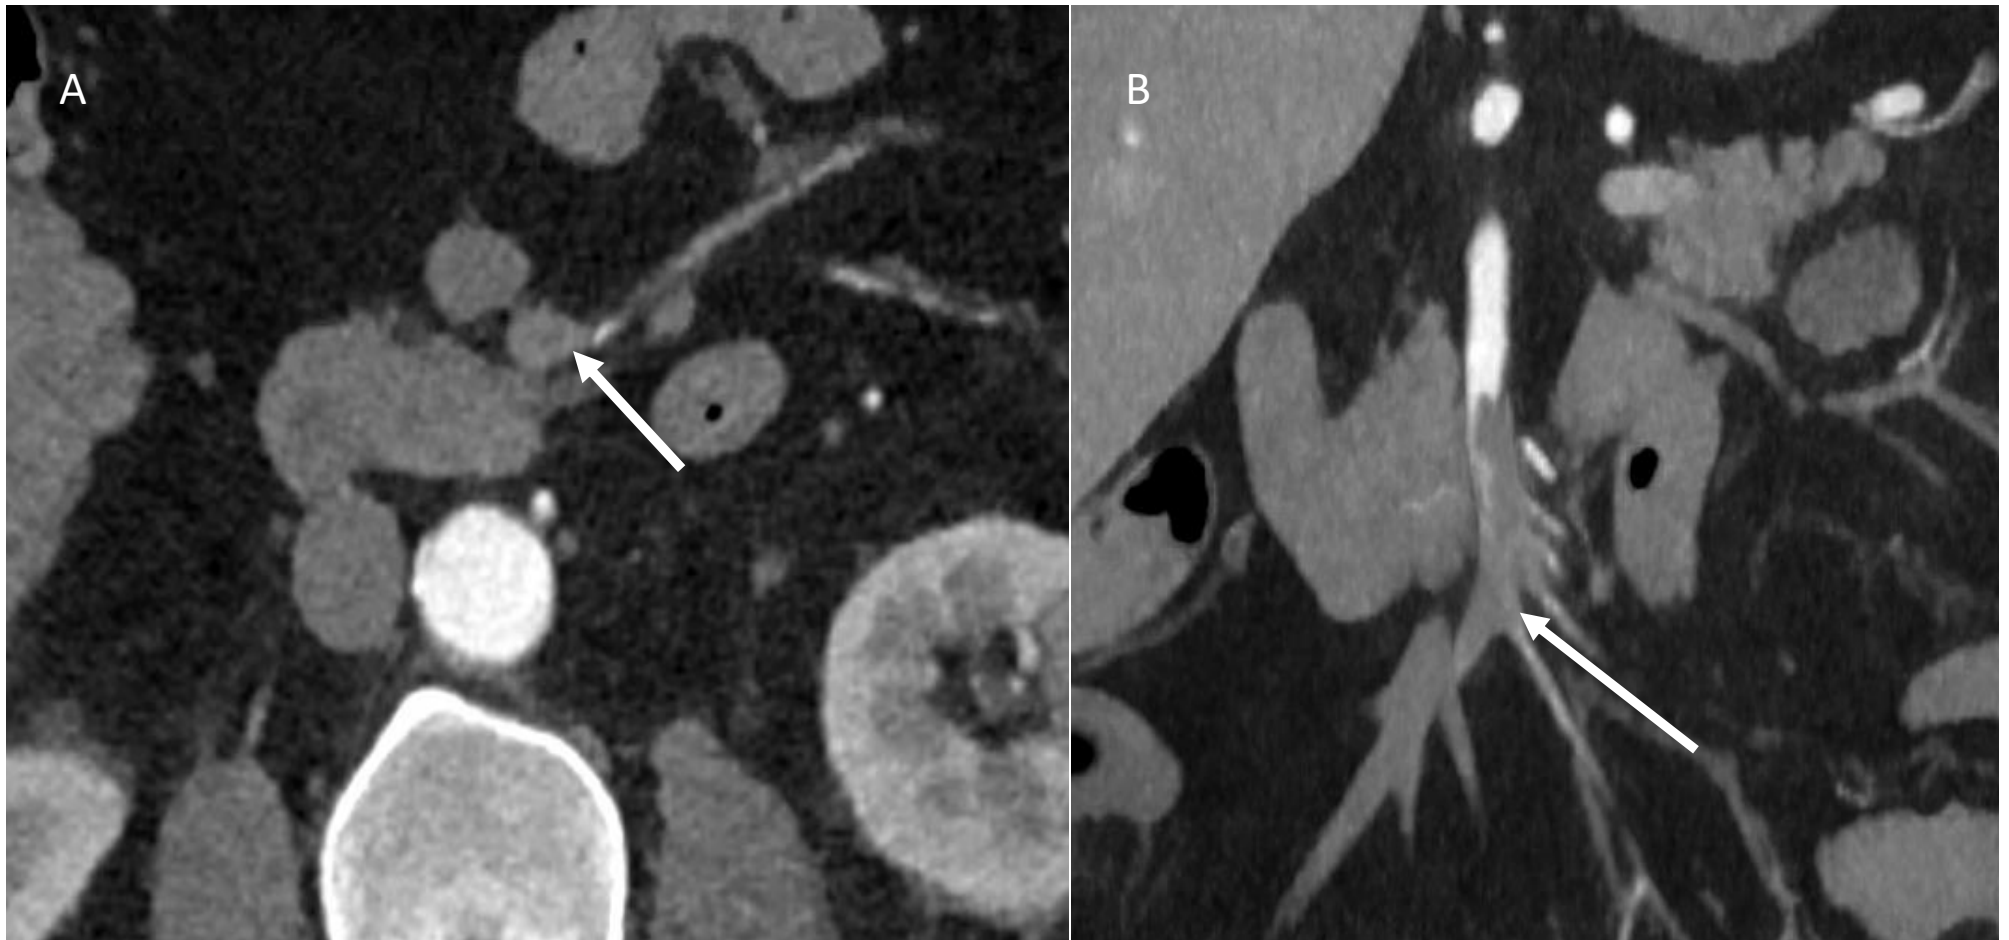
Abdominal CT-scan of a 79 years old patient with AMI showing an complete occlusion of the S0 segment of the SMA (arrow) : (A) axial view and (B) sagittal view
